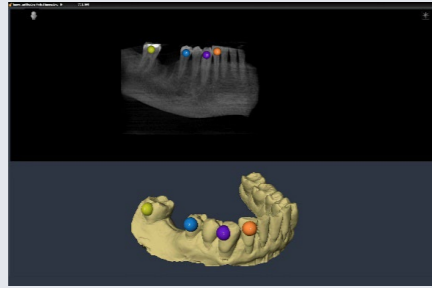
Matching of model data and CBCT in the SICAT SW
